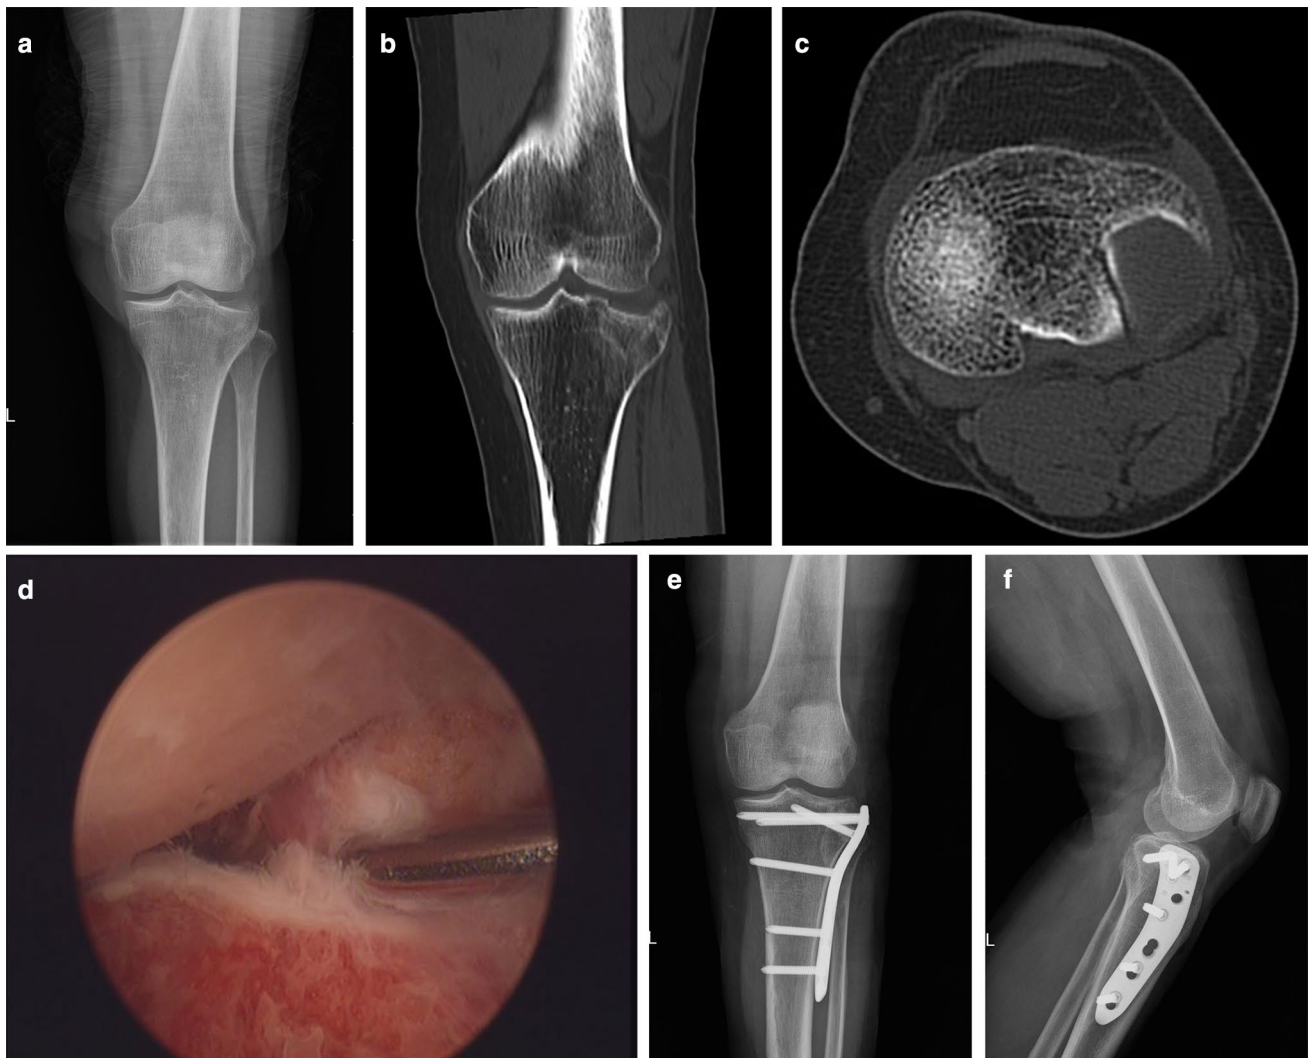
A 61-year-old female patient, traffic accident injury, Schatzker type III fracture of left tibial plateau. a Pre-operation radiograph. b, c CT-scan pre-operation. d Arthroscopic view of the articular surface before reduction. e, f Post-operation radiographs, achieved anatomical reduction
